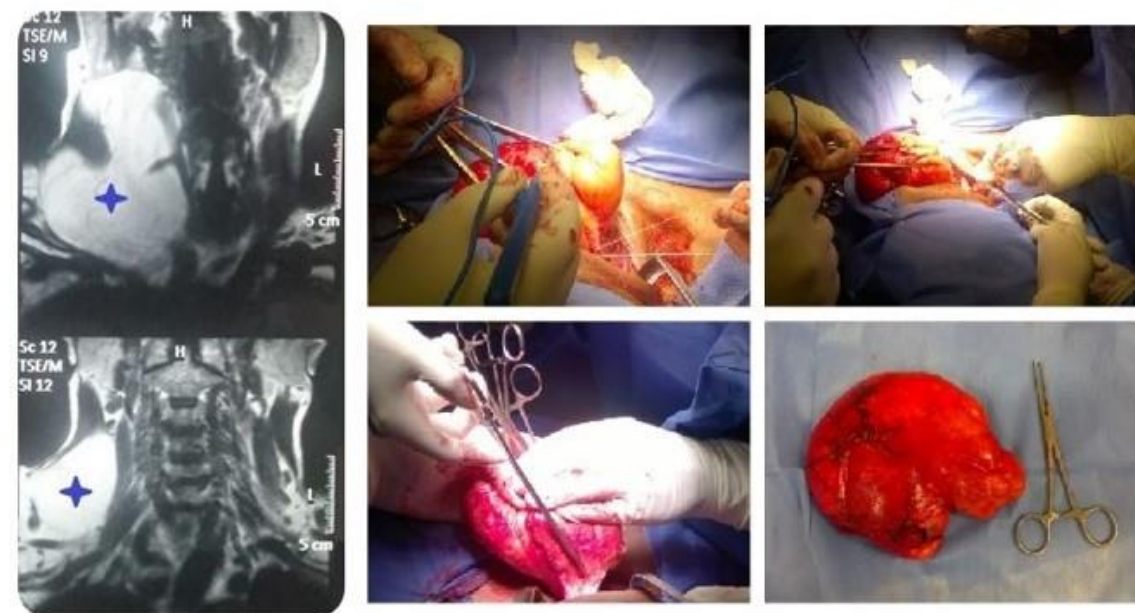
54-year-old male patient. 6 years of evolution and slow growth. MRI. Lipoma in STIR sequence of fat suppression is confirmed.
